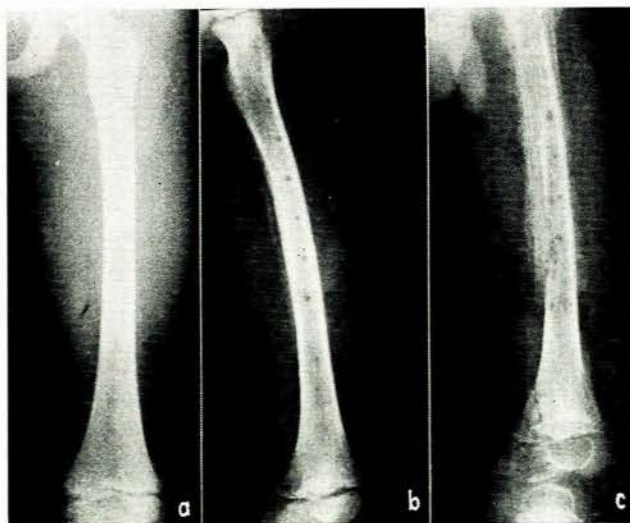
X-ray photo of left femur (case 3). (a) On admission. No bone pathology detectable but subperiosteal mass with extensive soft tissue swelling and oedema noted. (b) 2 weeks later. Note drill holes. Marked cortical bone destruction with periosteal new bone formation. (c) 2 months after admission. Marked osteoporosis with fracture and destruction of femoral metaphysis. Complete sequestration of femoral cortex. Note also periosteal reaction of ischial ramus.
